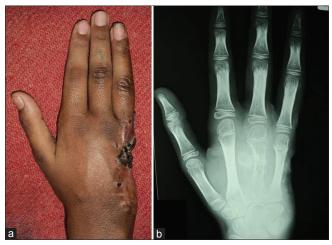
(a) Clinical photograph at followup after 3 months shows discernible fullness over dorsum of the hand. (b) Radiograph of hand anteroposterior view showing destruction of the third metacarpal with little periosteal reaction
